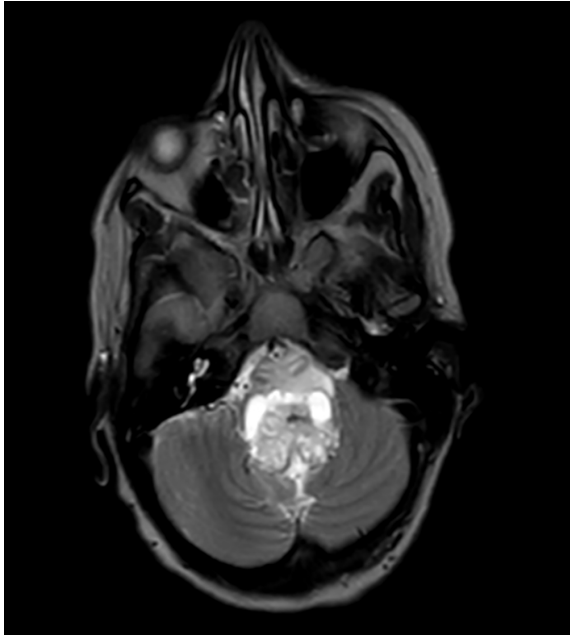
The image shows a brain MRI of a 23-week pregnant patient with a pontine tumor and its involvement of brain structural components. There is a 27*31 mm mass in the fourth ventricle with internal cystic components, with hydrocephaly due to mass effect. Ependymoma and subependymoma tumors are in the differential diagnosis.
